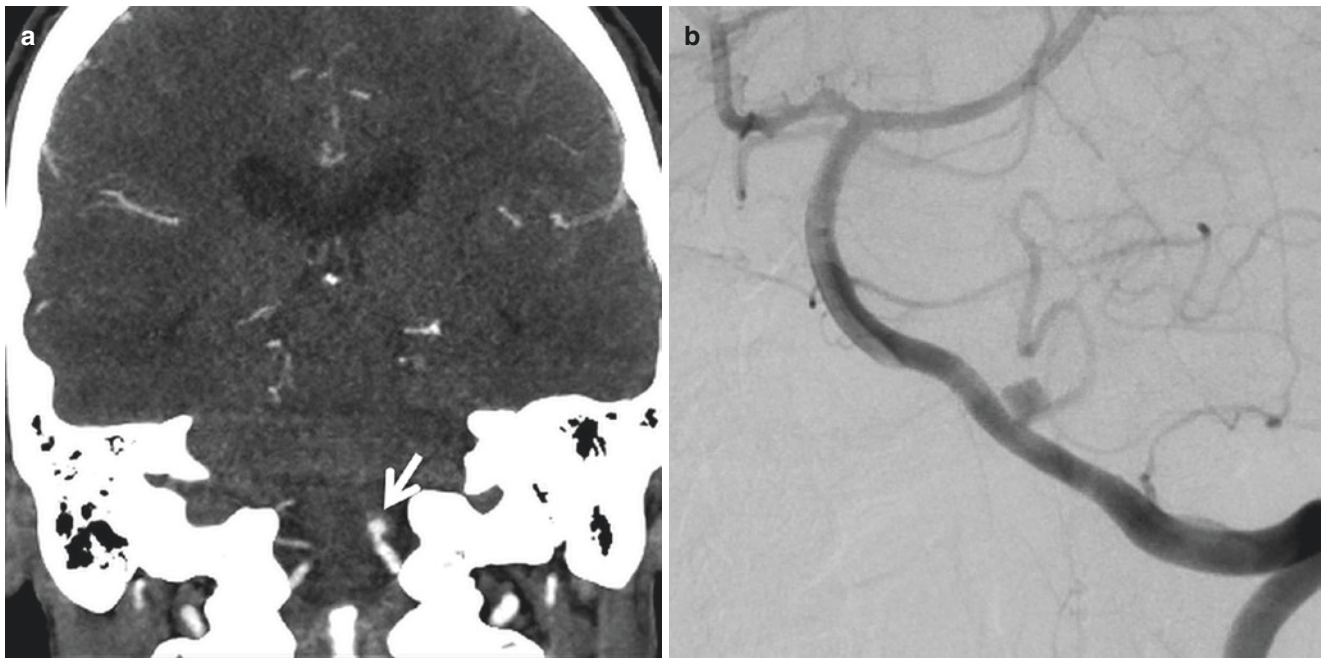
PICA aneurysm. Coronal CTA (a) demonstrates an aneurysm at the left PICA origin, confirmed by DSA (b)
